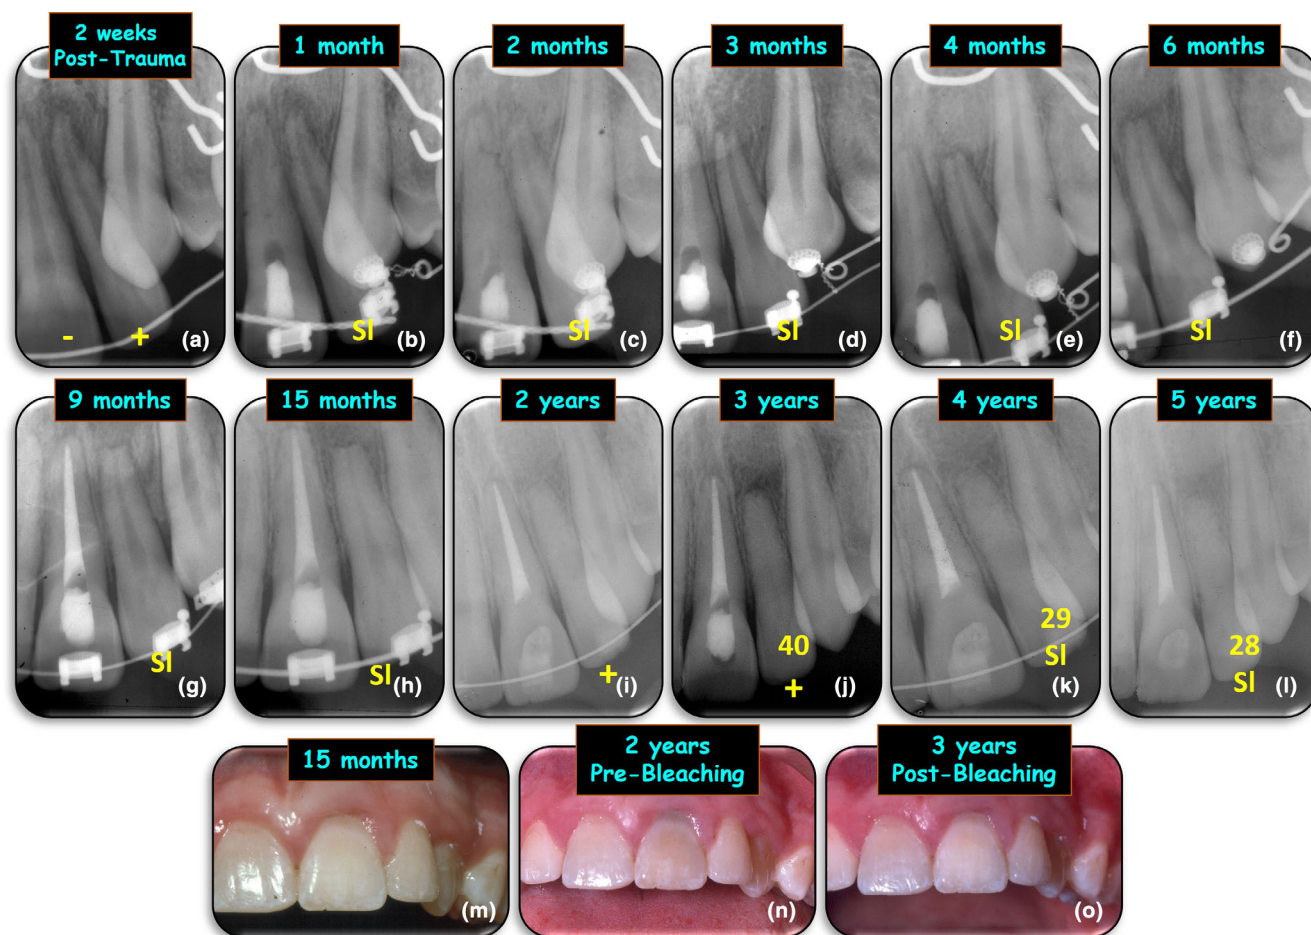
Example of a tooth that had transient apical breakdown. The maxillary left central and lateral incisors (teeth 21 and 22) of a 14-year-old male were laterally luxated when he fell off his bicycle. The two teeth were repositioned and splinted by his orthodontist approximately two hours after the accident. Two weeks later, the 21 had pain and swelling indicating pulp necrosis and an infected root canal system so root canal treatment was commenced. The 22 was monitored with regular clinical examinations, pulp testing and radiographs. The 22 responded slowly (compared to other teeth) to carbon dioxide dry ice pulp sensibility testing and there were radiographic signs of remodelling of the apex of the root, including opening of the apical foramen before it subsequently closed again. The periapical region also showed changes with a radiolucency which subsequently resolved, indicating transient apical breakdown. The pulp also underwent pulp canal calcification. The 21 was root-filled after 9 months of intracanal medication to prevent external inflammatory resorption. It was subsequently internally bleached as the crown discoloured. (a) 2 weeks after the injuries occurred; (b) Review after 1 month; (c) Review after 2 months; (d) Review after 3 months; (e) Review after 4 months; (f) Review after 6 months; (g) Review after 9 months; (h) Review after 15 months; (i) Review after 2 years; (j) Review after 3 years; (k) Review after 4 years; (l) Review after 5 years; (m) Clinical appearance 15 months after the injury; (n) Clinical appearance 2 years after the injury; the 21 has discoloured; (o) Clinical appearance 3 years after the injury and following internal bleaching of the 21. Footnote – KEY: yellow numerals represent results of electric pulp tests (scale 1–80); yellow ‘+’ sign indicates the tooth responded to carbon dioxide dry ice testing; yellow text ‘SI’ indicates a slow response to the carbon dioxide dry ice test (compared to other teeth); yellow ‘-’ sign indicates no response to the carbon dioxide dry ice test.
